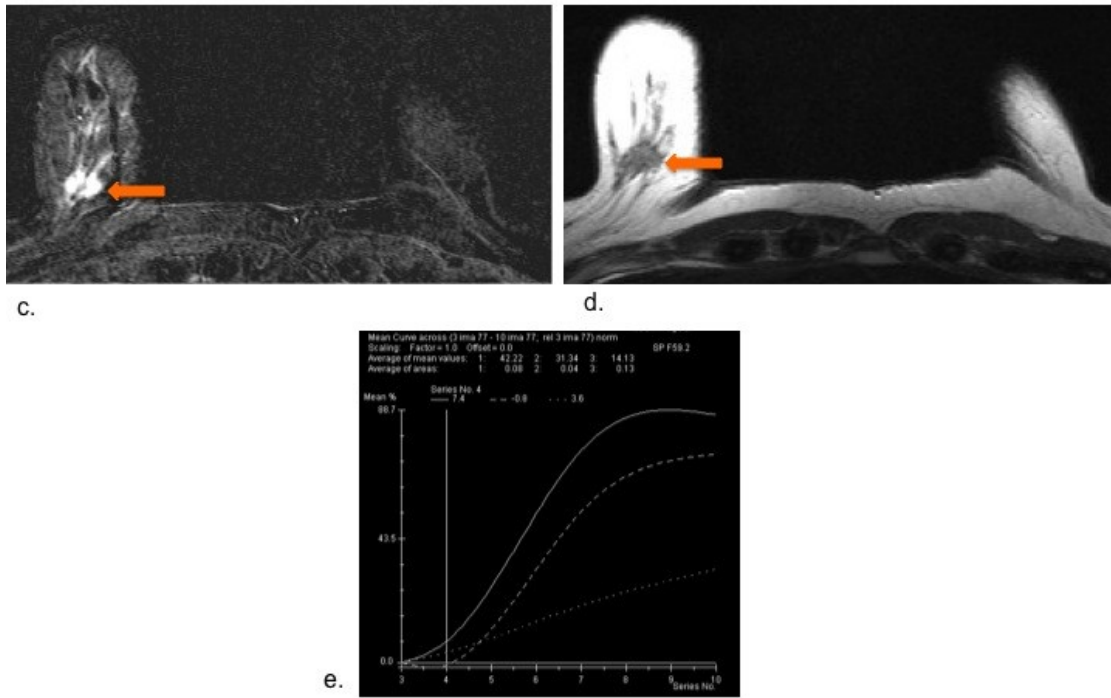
Breast MRI case
